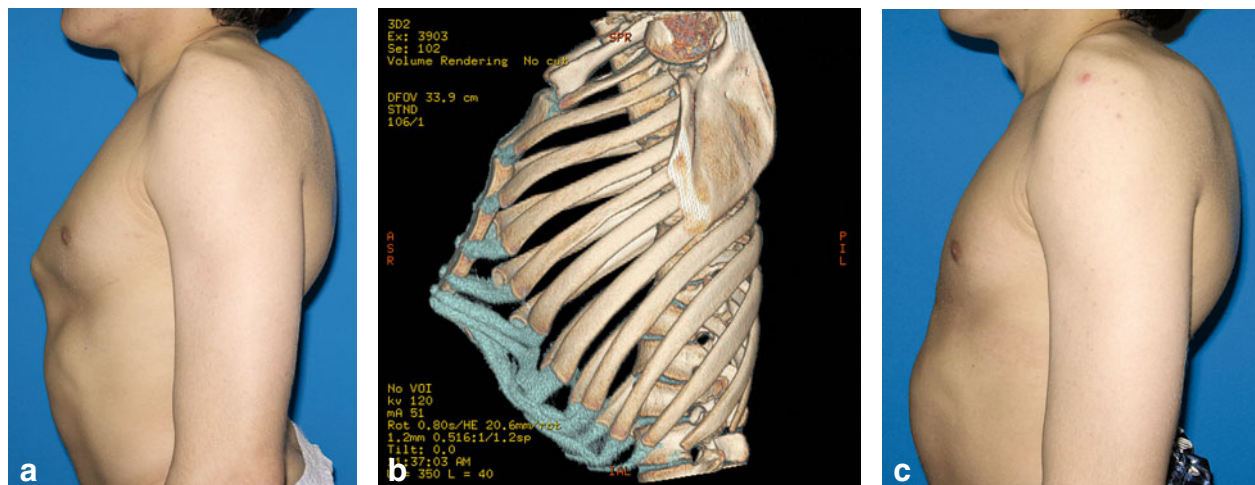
20-Year-old male with osteodystrophic microsomia and an extensive chondrogladiolar keel chest preoperatively (a) and the corresponding CT-scan depicting the extent of deformity (b). Postoperative view with very pleasing aesthetic result
